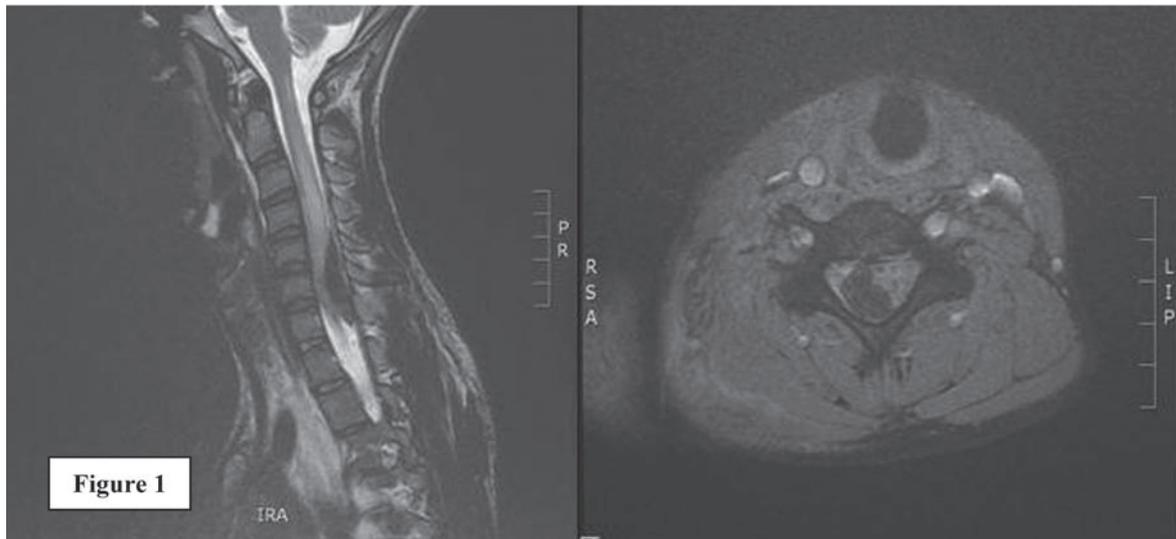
MRI scan showed a subdural haematoma collection extending from C5 to C7 which compressed the spinal cord. The spinal cord was shifted to the left side.
